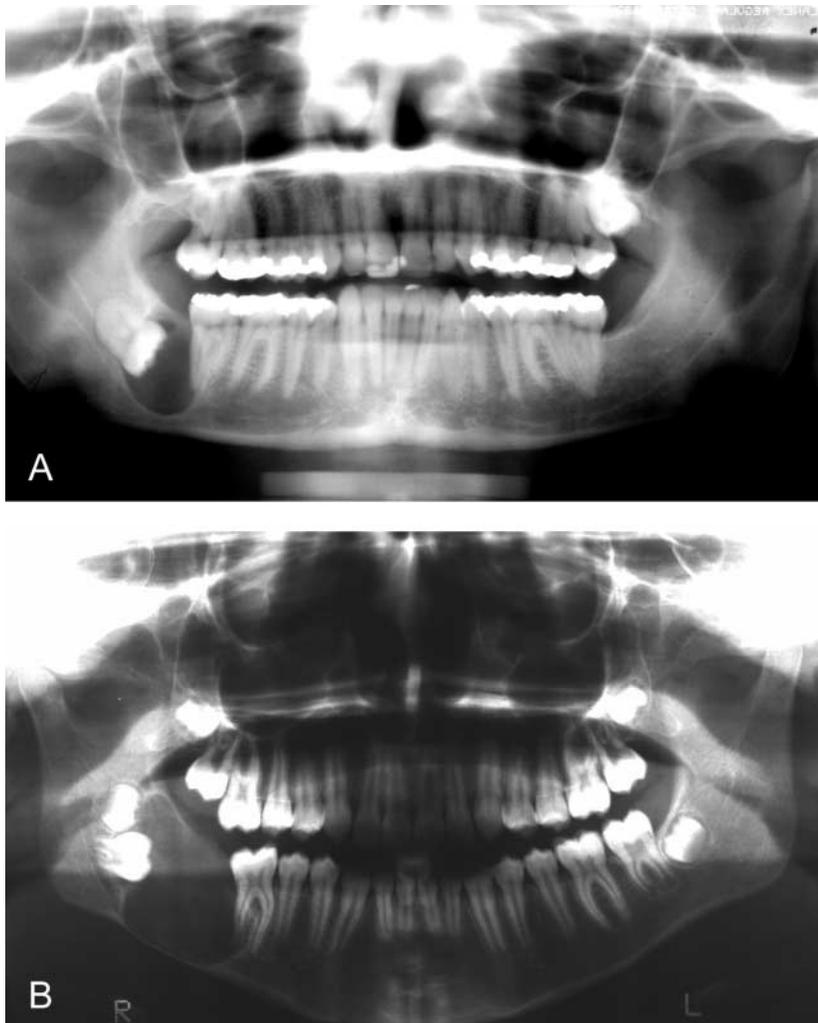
(A) All 12 examiners diagnosed correctly this typical case of dentigerous cyst in both radiographic methods. (B) This case of ameloblastoma had only 16% of correct diagnosis in both methods
